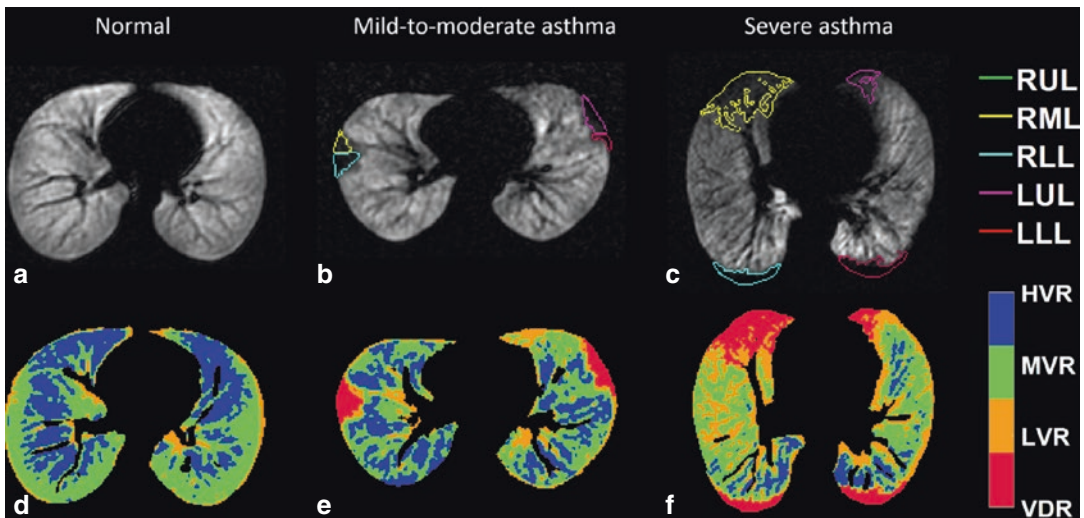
Typical examples of segmented defects and the corresponding ventilation maps at middle slices of three subjects on HP ^3He MRI. The segmented defects for a normal subject (a), mild-to-moderate asthma (b), and severe asthma (c) are outlined with color-coding by lung lobe: right upper lobe (RUL) in green, right middle lobe (RML) in yellow, right lower lobe (RLL) in cyan, left
